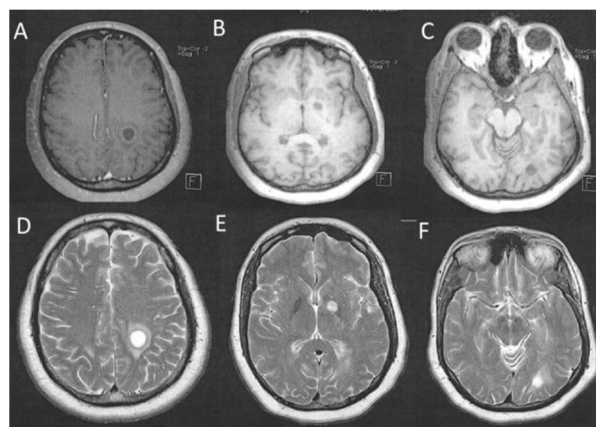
MRI of brain showing axial T1-weighted (A-C) hypodense lesions of the left centrum semiovale(A), left basal ganglia(B) and left occipital lobe(C). Axial T2-weighted (D-F) views show multiple hyperdense lesions corresponding to the same locations. Perilesional vasogenic edema is seen.
